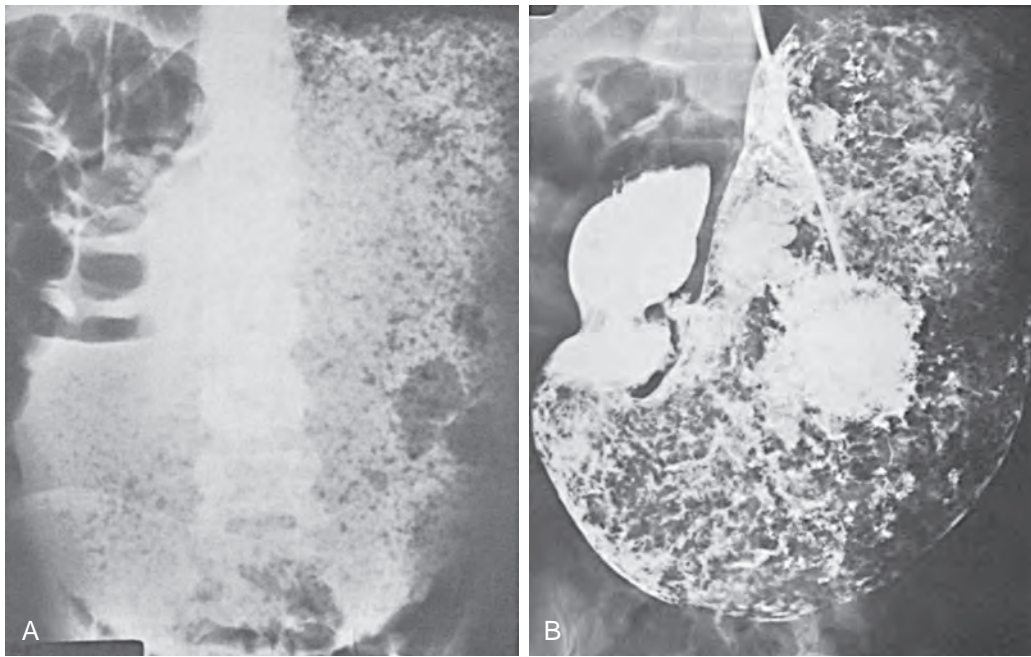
Chronic gastric dilation caused by severe electrolyte and acid-base imbalances. A. Abdominal radiograph shows a marked amount of particulate material in a massively dilated stomach extending inferiorly into the pelvis. B. Barium study confirms the presence of marked gastric dilation.
